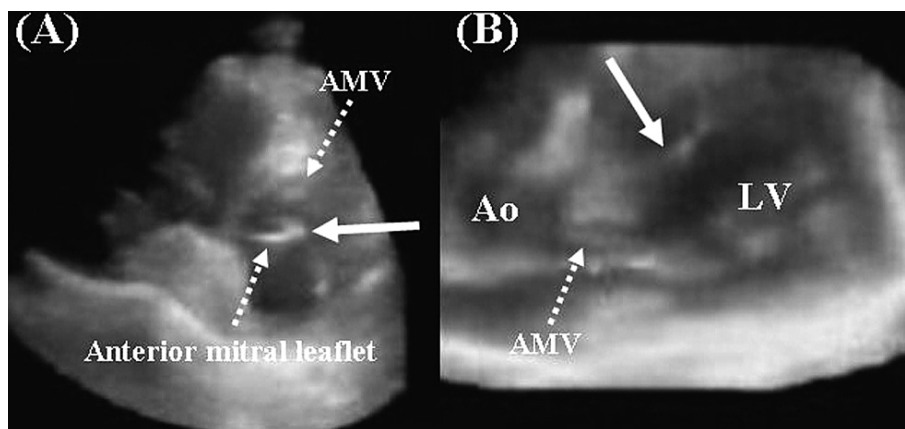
Real-time three-dimensional echocardiograms
